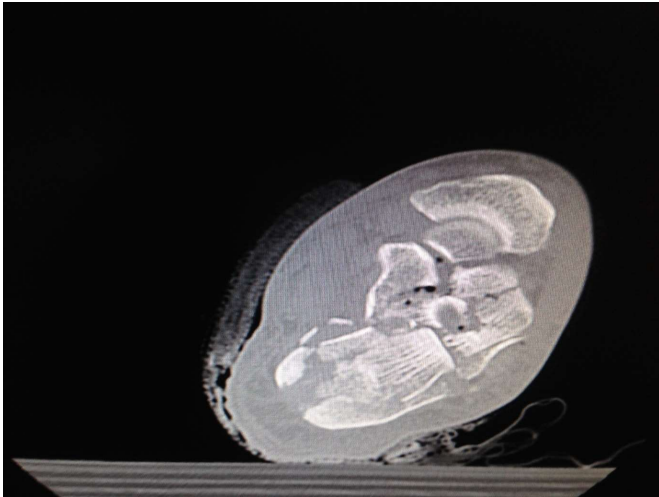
Computed tomography view.
